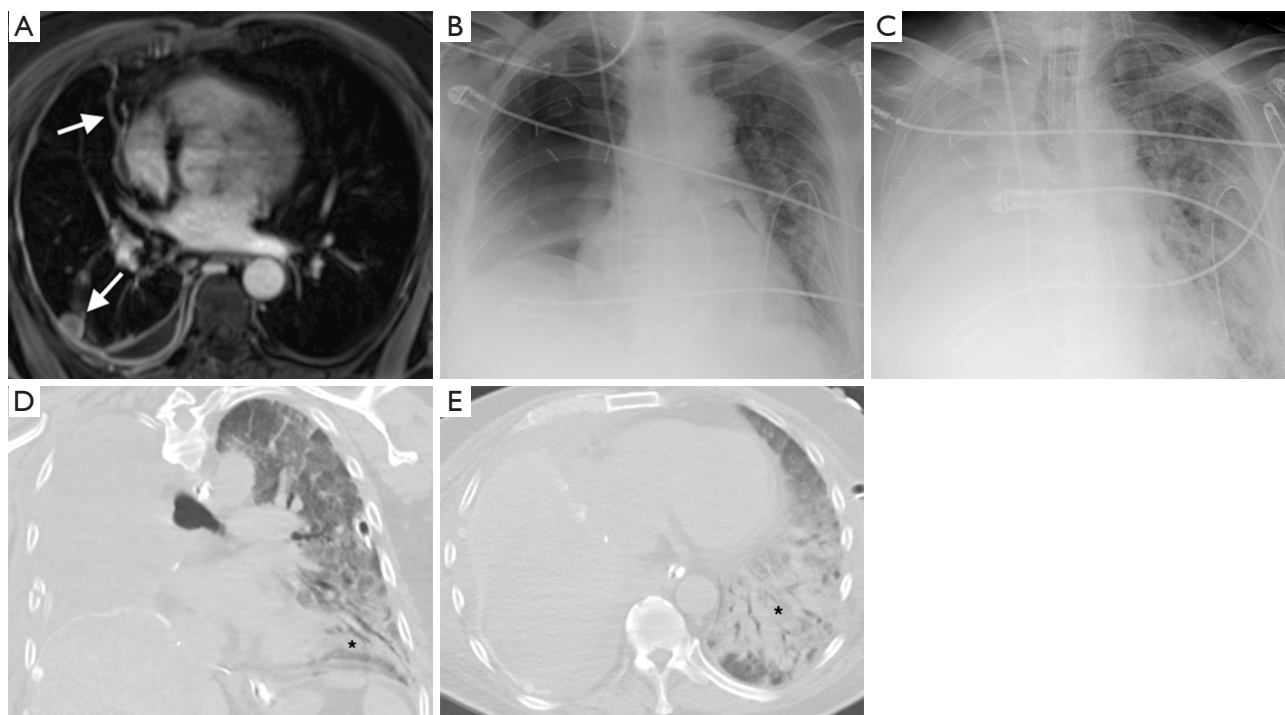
A 72-year-old man with a right epithelioid mesothelioma. Axial image (A) from a T1 weighted fat suppressed post gadolinium sequence from preoperative MRI demonstrates enhancing nodular right pleural thickening (arrows) with a small pleural effusion. Day 1 post-op CXR (B) demonstrates a gas filled right hemithorax post right EPP with pericardial and diaphragmatic reconstruction. The patient developed hypoxia post-surgery, with a CXR on postop day 7 (C) demonstrating worsening air space opacities in the left mid and lower zone, concerning for pulmonary edema or pneumonia. Note the progressive fluid filling of the right pneumonectomy space. Coronal (D) and axial (E) images from a non-contrast CT thorax on day 12 post-surgery demonstrate diffuse ground glass opacities throughout the left lung with left lower lobe consolidation with bronchial dilatation (star) concerning for ARDS. MRI, magnetic resonance imaging; CXR, chest radiograph; EPP, extrapleural pneumonectomy; CT, Computed tomography.
